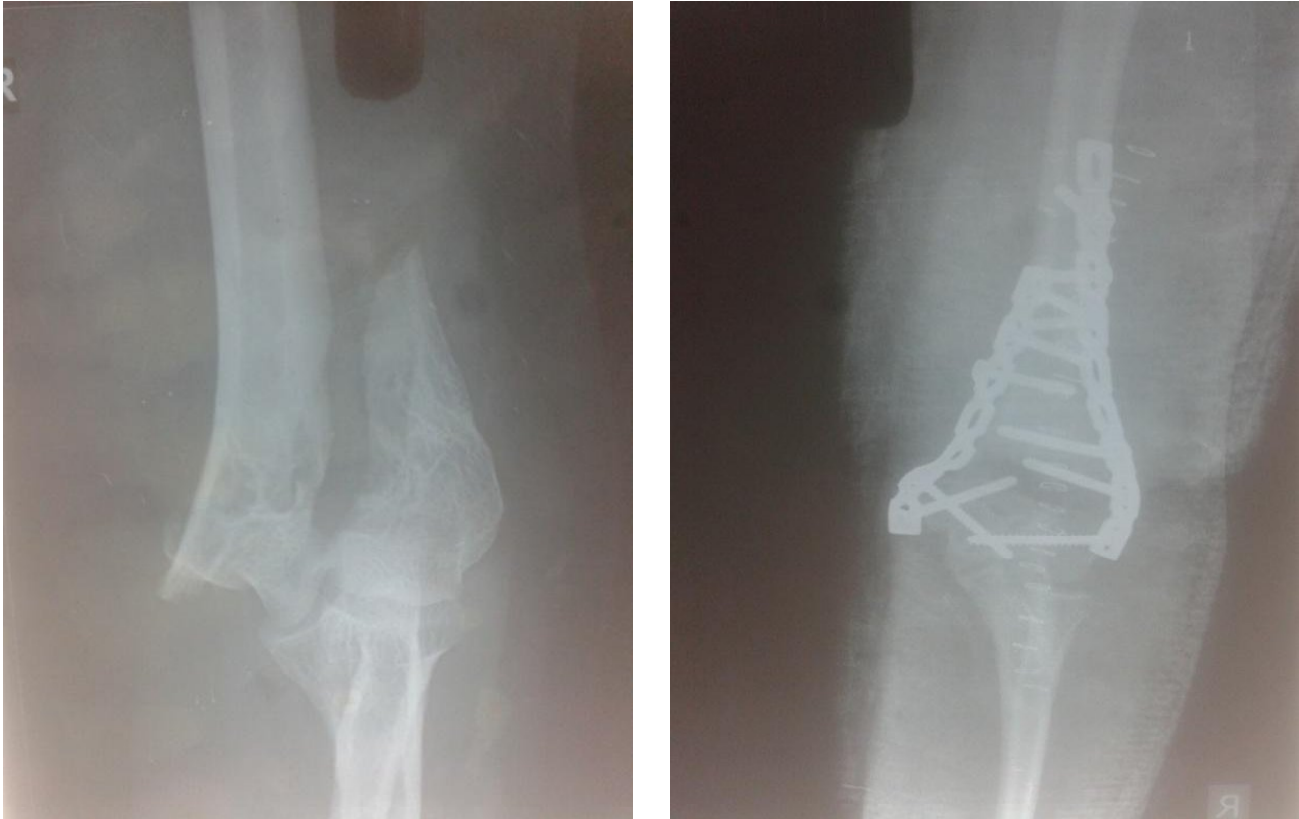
AP view of Xray showing intercondylar fracture humerus (pre operative and post operative)
